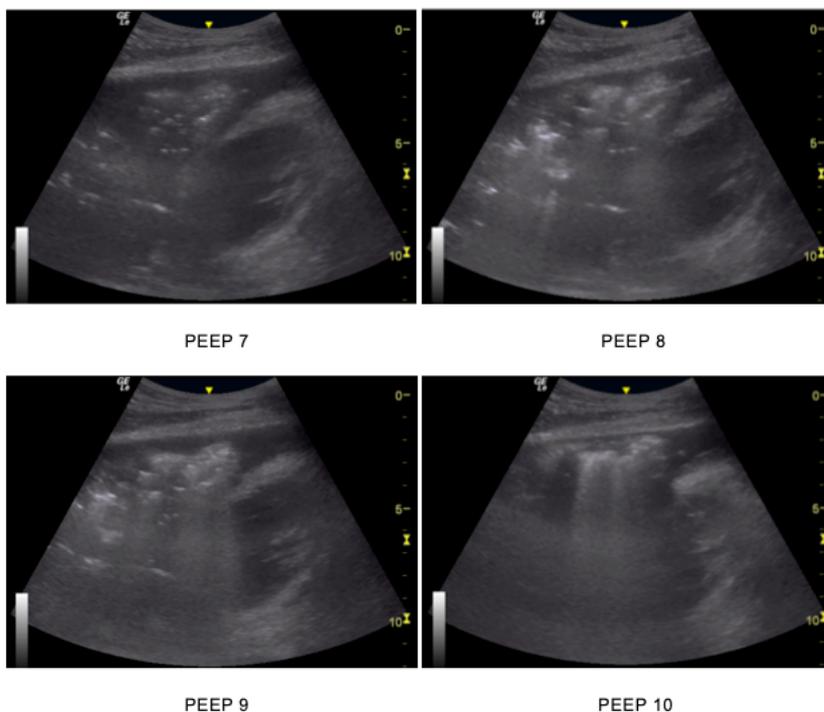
Ultrasound PEEP assessment
